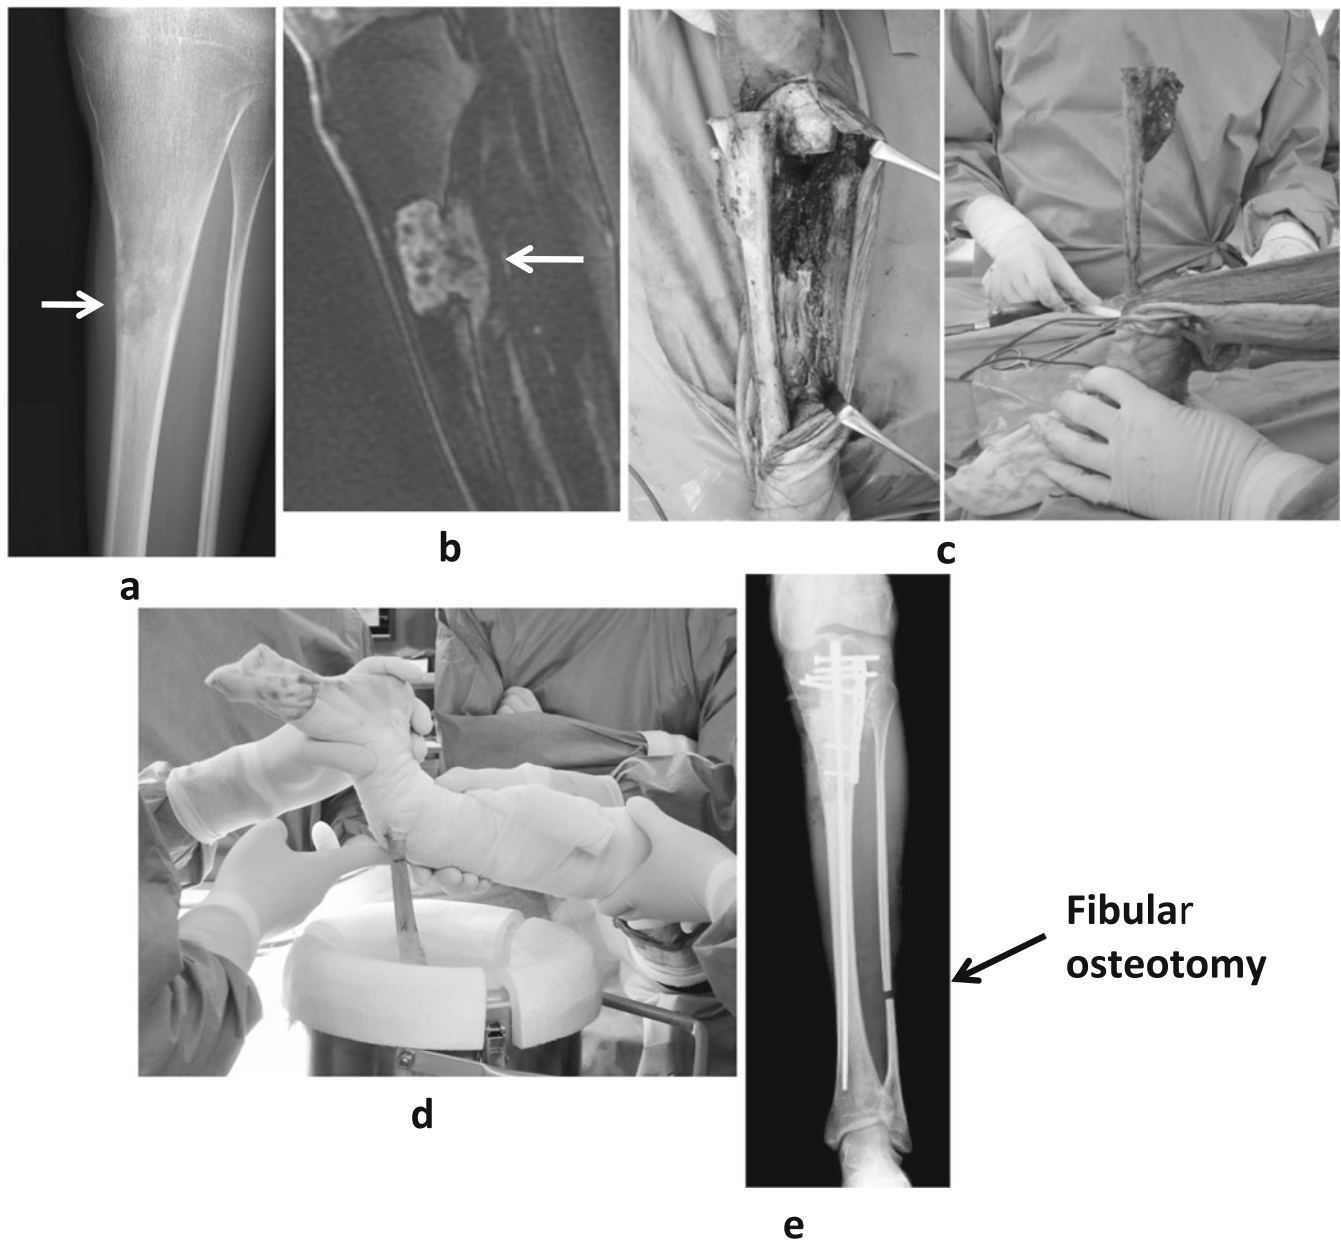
Case 16, an 18-year-old man with an osteosarcoma (*arrows*) of the left diaphyseal tibia. a Preoperative radiograph. b Preoperative MRI scan. c One-site osteotomy of the proximal tibia and subsequent fibular osteotomy at the rotated
